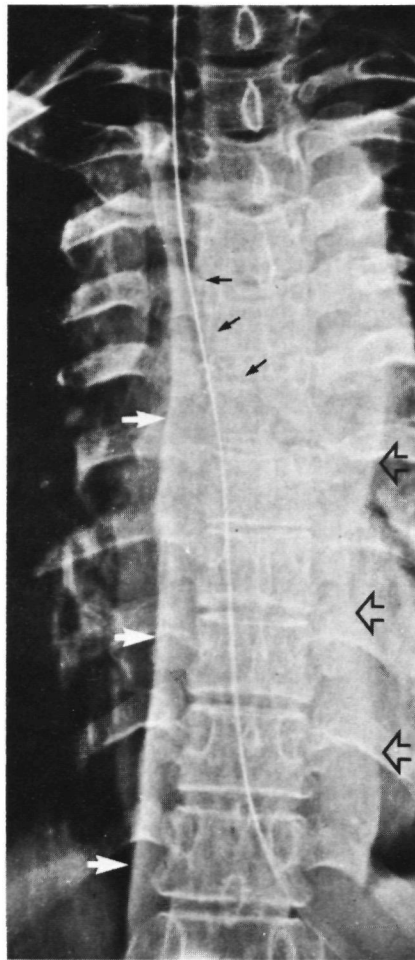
13 Female, 47 years, car-driver, TAR. Death during celiotomy due to massive bleeding. Chest X-ray: broadening of left (open black arrows) and right (white arrows) paraspinal lines. Note also displaced trachea (black arrows) and nasogastric tube. Widening of the mediastinal shadow (11 cm). Widened right paratracheal stripe.
